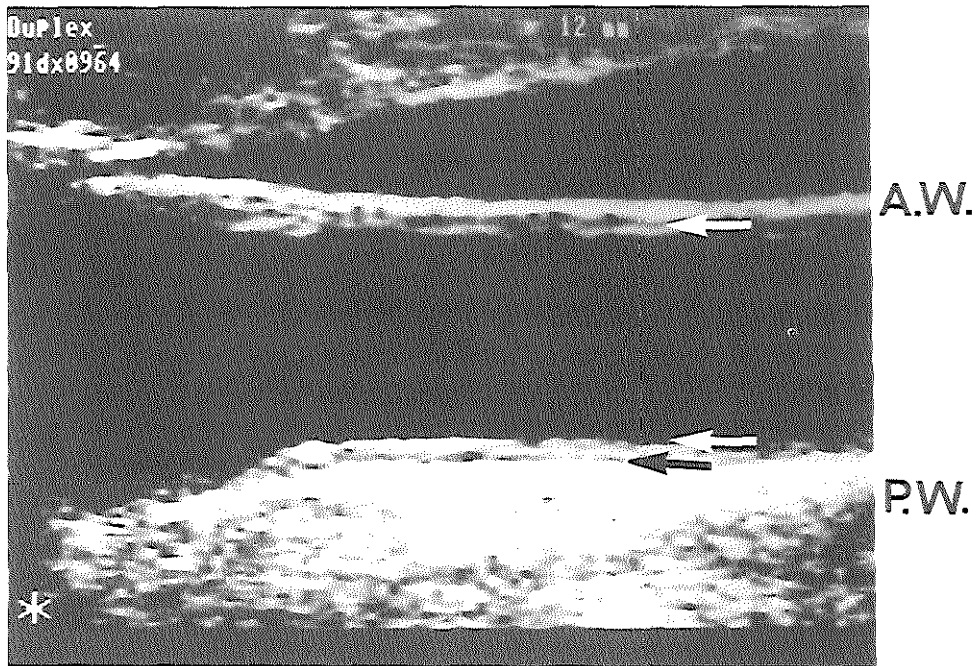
Characteristic longitudinal ultrasound image of the distal common carotid artery.
